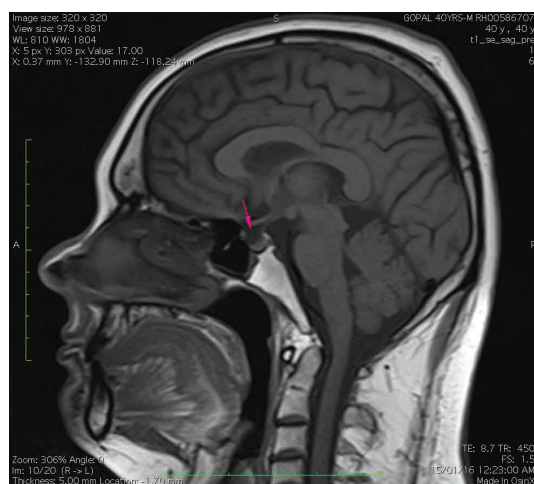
MRI of Pituitary (Arrow pointing normal pituitary)
